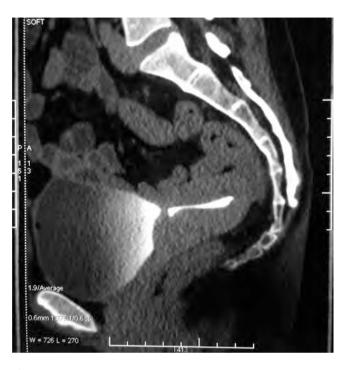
CT scan showing fistulous connection between posterior wall of bladder and uterus
